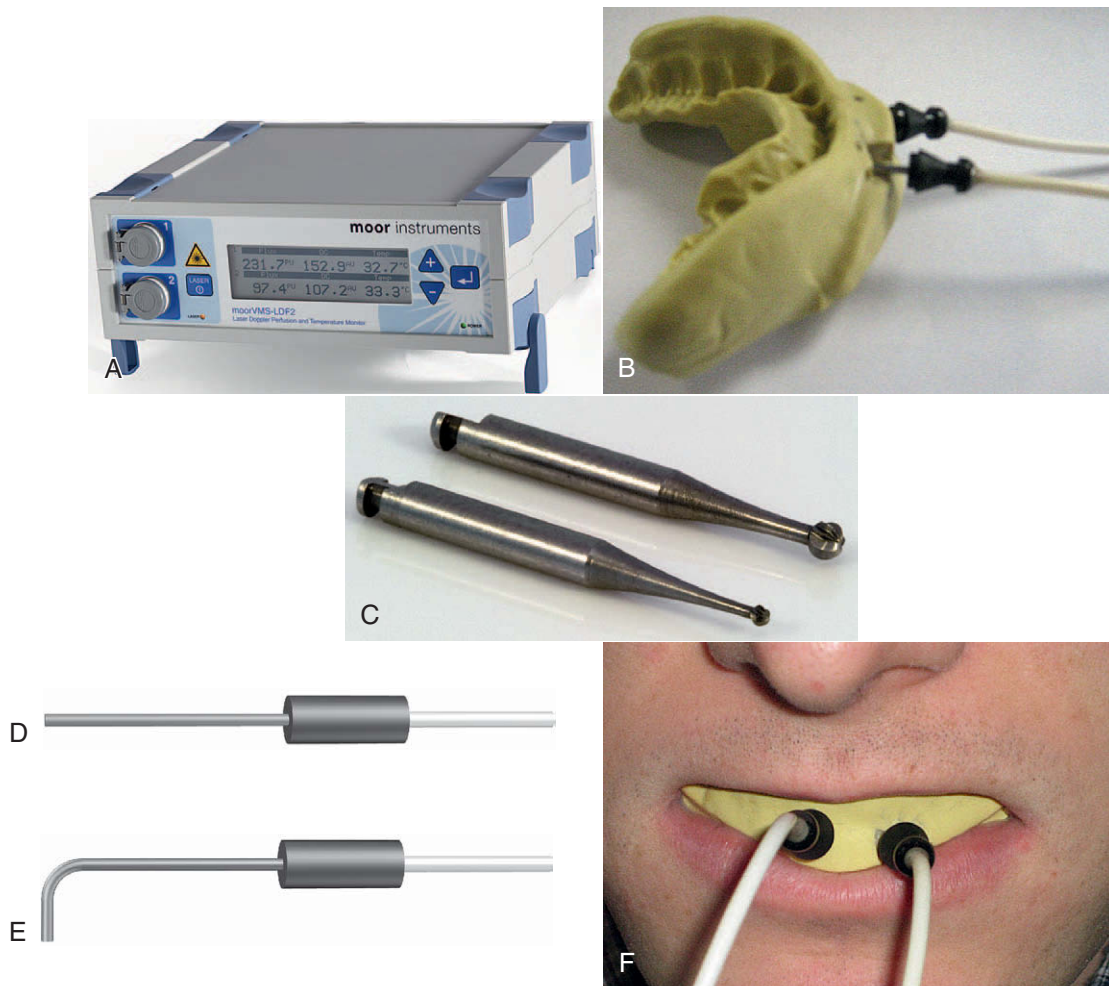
• A, Laser Doppler flowmeter unit. B, Mold made of quick-set putty with two laser Doppler probes embedded. C, Slow-speed round burs used to make holes in putty for placement of probes. D and E, Laser Doppler probes for assessment of blood flow in anterior teeth (D) and posterior teeth (E). F, Quick-set putty with dental probes in position in the mouth.
